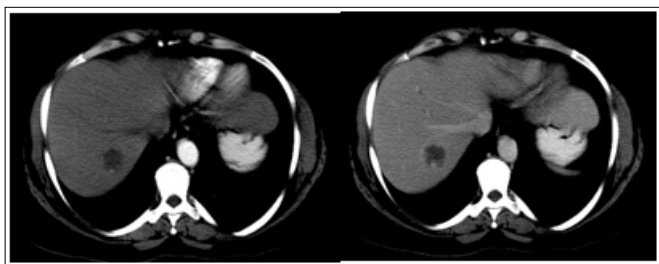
CT AP Hemangioma-Radiographic Findings
